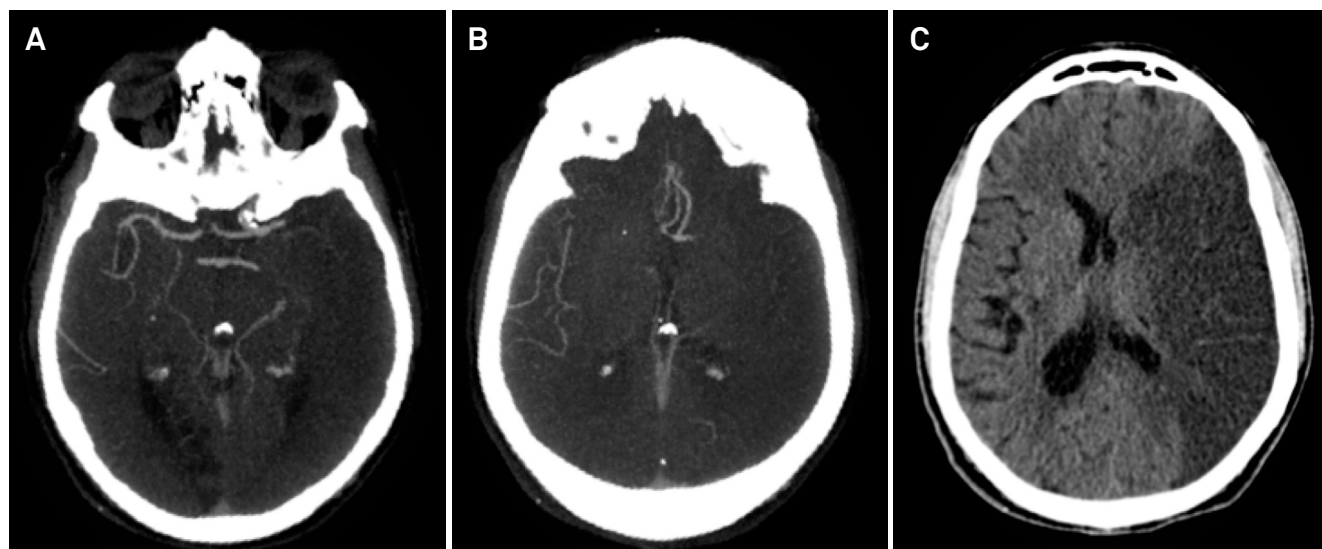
Proximal occlusion with faint contrast opacification restricted to the distal superficial branches (Miteff grade 1 – M1). (A) A left M1 occlusion was found on computed tomography angiography (CTA), and the collateral circulation in the middle cerebral artery (MCA) territory was considered absent (B). (C) Follow-up non-contrast compute tomography (NCCT) 24 hours later demonstrating a malignant infarct. This patient died 3 days later.
